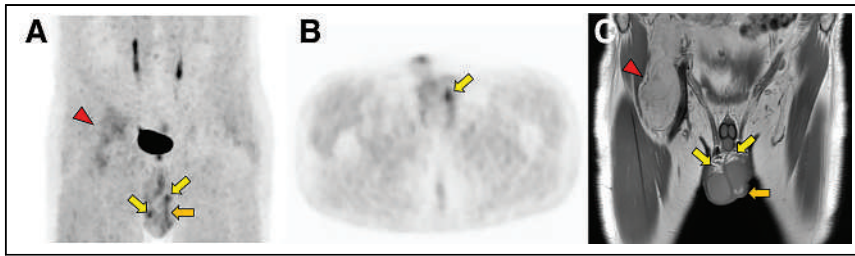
Subject 2 (43-y-old man) from Table 1. Shown are [^{68}Ga]Ga-FAPI-46 maximum-intensity projection coronal PET (A), axial PET (B), and coronal T1-weighted MR images (C). Moderate uptake is demonstrated bilaterally in epididymal heads (yellow arrows). Mild uptake is demonstrated in left epididymal body/tail (orange arrows). There was mild uptake in right epididymal body/tail (not shown). Epididymal tissue was demonstrated on MRI, with no epididymal disease reported. Biopsy-proven hibernoma with mild uptake was noted (arrowheads).
